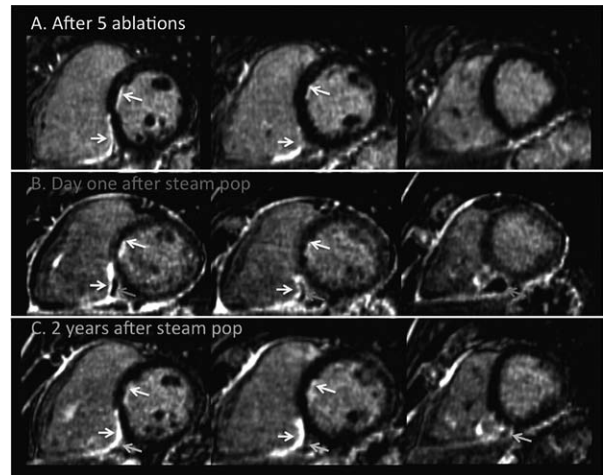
MRI data before and after sixth ablation procedure. A, LGE images acquired on the day before the procedure show subendocardial enhancement related to a nontransmural scar from previous ablations, on both sides of the interventricular septum and on the inferior RV wall (yellow arrows). B, LGE images acquired on day 1 after the procedure show an intramural hematoma in the septum at the site of steam pop (pink arrows). Images also show pericardial enhancement related to an inflammatory response to pericardial access during the procedure, but no pericardial bleeding. C, LGE images 2 years after the procedure show a complete resolution of the hematoma (blue arrows), and the persistence of a nontransmural scar on both sides of the septum. LGE indicates late gadolinium enhancement; and RV, right ventricular.
